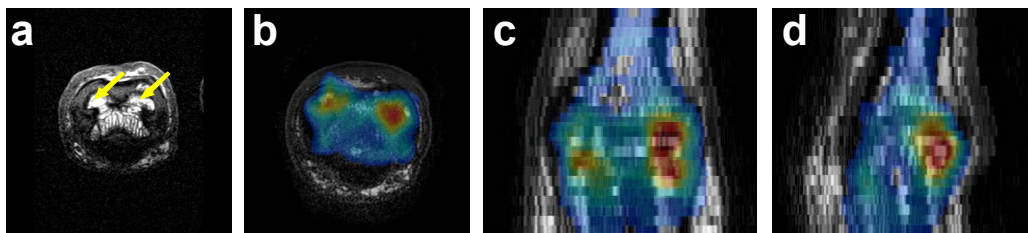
Axial (a and b), coronal (c) and sagittal (d) MR images in the region of the proximal interphalangeal joint in a patient with osteoarthritis. Images b-d also show registered PET data displayed as a colour overlay with ‘warm’ colours indicating relatively high ¹⁸F uptake (see text).
